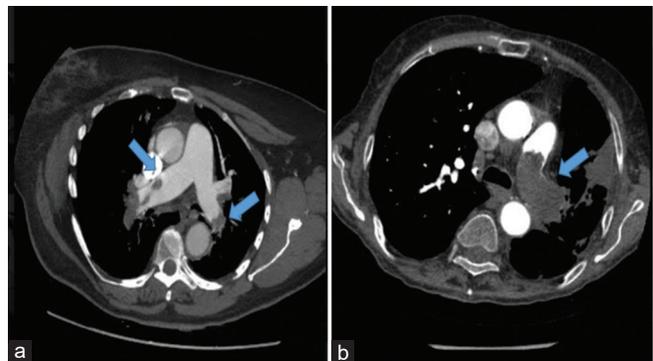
Contrast-enhanced chest computed tomography of pulmonary embolism; arrows show bilateral (a) and left main pulmonary artery (b) embolism
